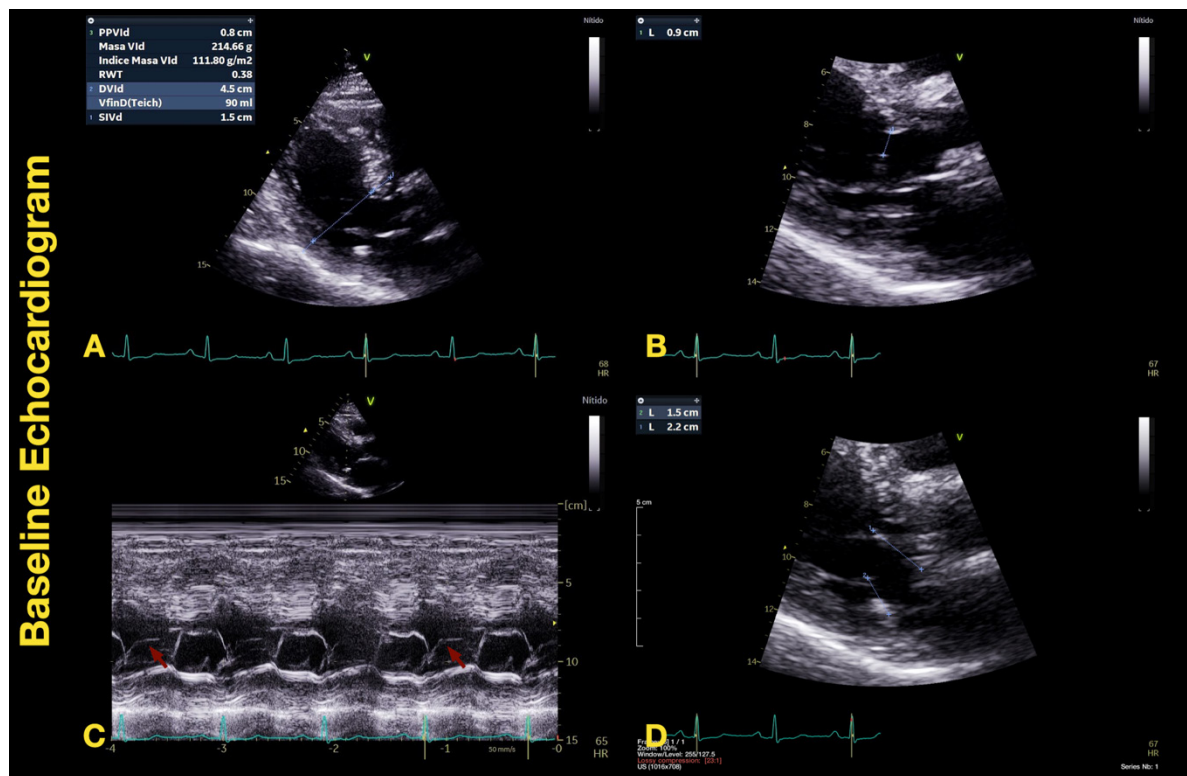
Baseline echocardiogram. A. Basal septal hypertrophy (15 mm) and mildly increased left ventricular mass (112 g/m²); B. Coaptation-to-septum distance of 9 mm; C. SAM on M-mode (red arrows); D. Elongated mitral leaflets.
